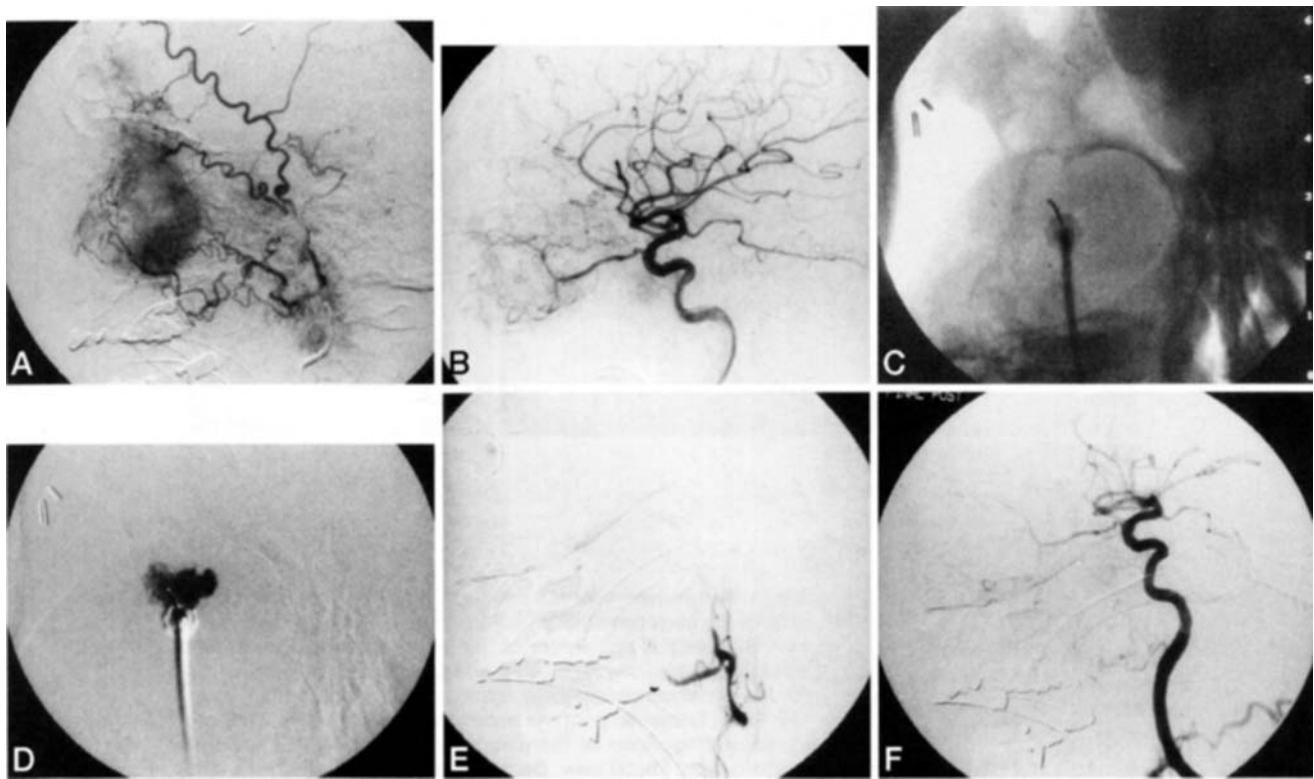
Sixty-eight-year-old man with recurrent interosseous meningioma involving the right orbit and maxillary sinus. A. Selective angiogram of the right external carotid artery, lateral view. Numerous small branches of the sphenopalatine, middle meningeal, and superficial temporal arteries are observed to contribute to the hypervascularity. B. Selective angiogram of the right internal carotid artery, lateral view. Significant contributions from orbital branches of the ophthalmic artery are present. C and D. Frontal radiograph of right orbit, direct puncture angiogram of the meningioma, frontal view. A needle is shown traversing the right orbit, with its tip positioned deeply within the mass. The angiogram demonstrates a significant vascular compartment of the mass, amenable to embolization. E and F. Selective angiogram of the right external carotid artery, lateral view. No residual neovascularity is identified on the final control angiogram, after embolization.
